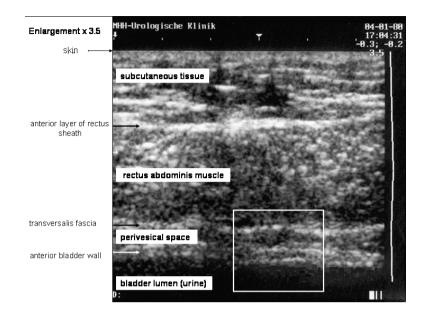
Ultrasound image of the anterior abdominal wall and anterior bladder wall with a 7.5 MHz linear array positioned suprapubically. At low magnification of the ultrasound picture (3.5 x), the anterior bladder wall can be identified.
